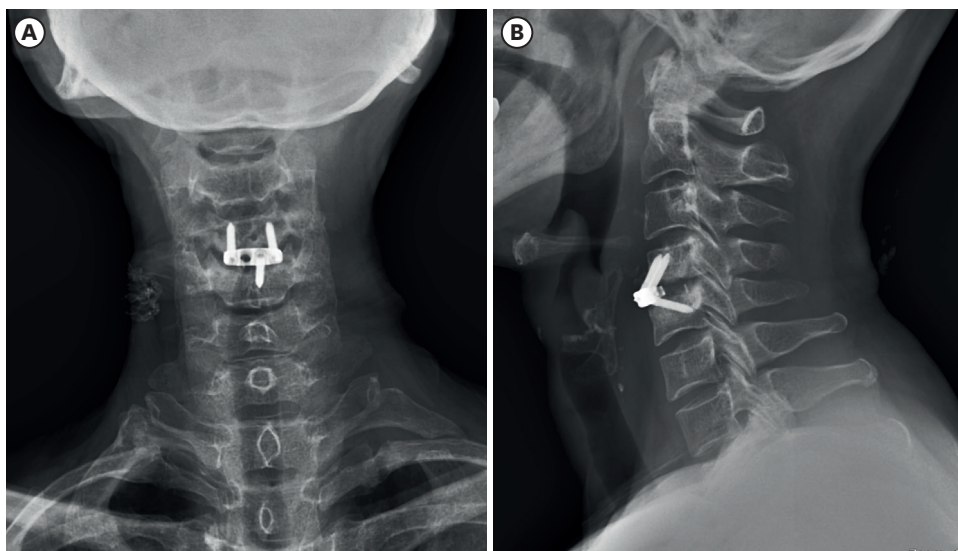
Cervical view is showing screw extrusion in the lower right from the ZERO-P spacer. (A) Anteroposterior and (B) lateral X-rays.
